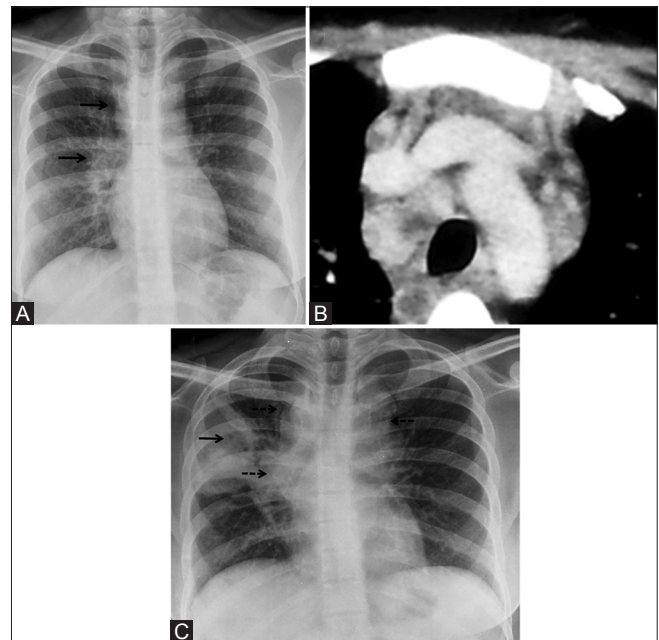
(A-C): 24-year old female presented with non-specific fever and breathlessness. (A) Chest X-ray (CXR) showed presence of right paratracheal and right hilar lymphadenopathy (black arrows). (B) Coned down axial contrast-enhanced CT (CECT) chest (mediastinal window) image showed discrete homogeneous pretracheal, right paratracheal, and prevascular lymphadenopathy. On lung window, there were perilymphatic nodules (not shown)—radiologically consistent with sarcoidosis. Patient was started on steroids. Three months later, she deteriorated with onset of productive cough and increasing breathlessness. (C) CXR revealed new-onset consolidation in right upper lobe with air bronchogram and cavitation (solid arrow) and increase in mediastinal and hilar lymphadenopathy (broken arrows). Sputum *acid fast bacilli* came out to be positive. Subsequently, anti-tubercular therapy was started following which she improved (not shown)
